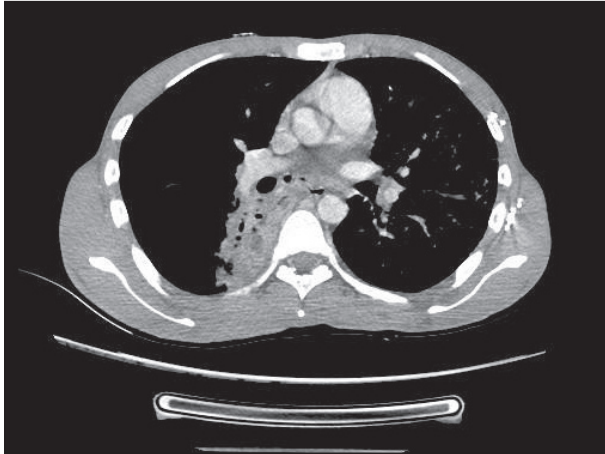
Chest computed tomography image showing the right lower lobe collapse and consolidation, and pockets of gas in the mediastinum
